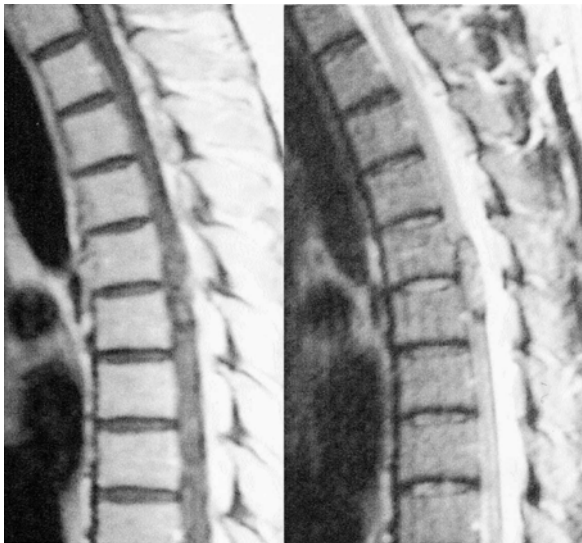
Magnetic resonance (MR) imaging revealed expansion of a tumor in the mid-thoracic region, including the right Th 5–6 nerve root area. *Left*, T1-weighted image; *right*, T2-weighted image
